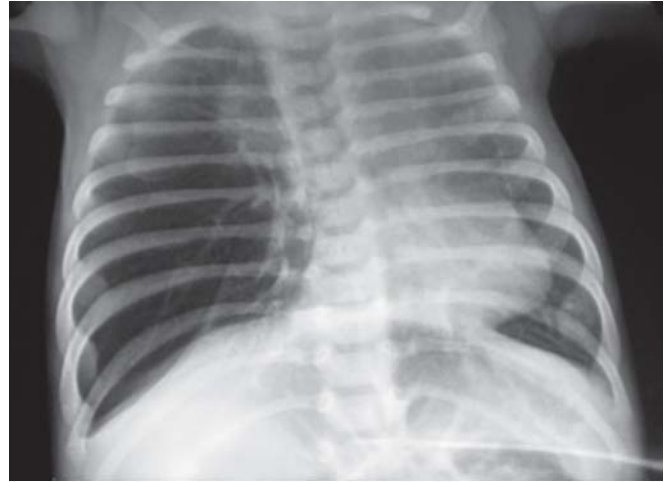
Chest X-ray of a 27 days neonate with CLE of right upper and middle lobe causing mediastinal shift to left. Note the presence of bronchovascular markings till periphery of right lung
